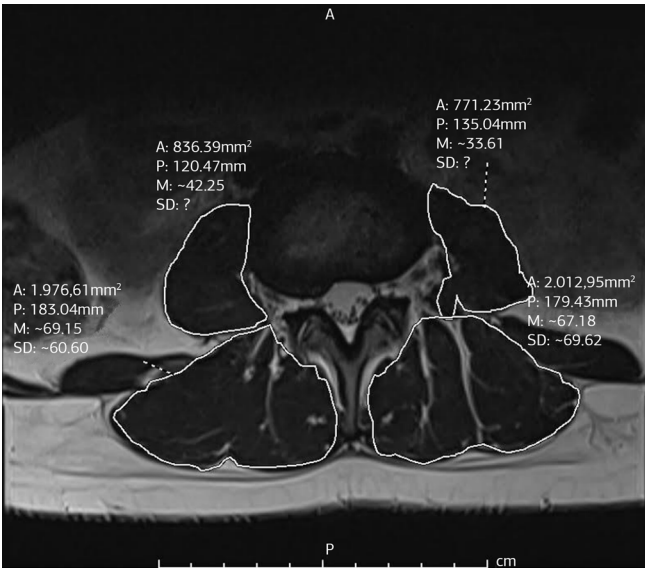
Measurements of the right and left PSOAS muscle volumes and the right and left lumbar extensor muscles of a patient on T2 weighted axial plane MRI
